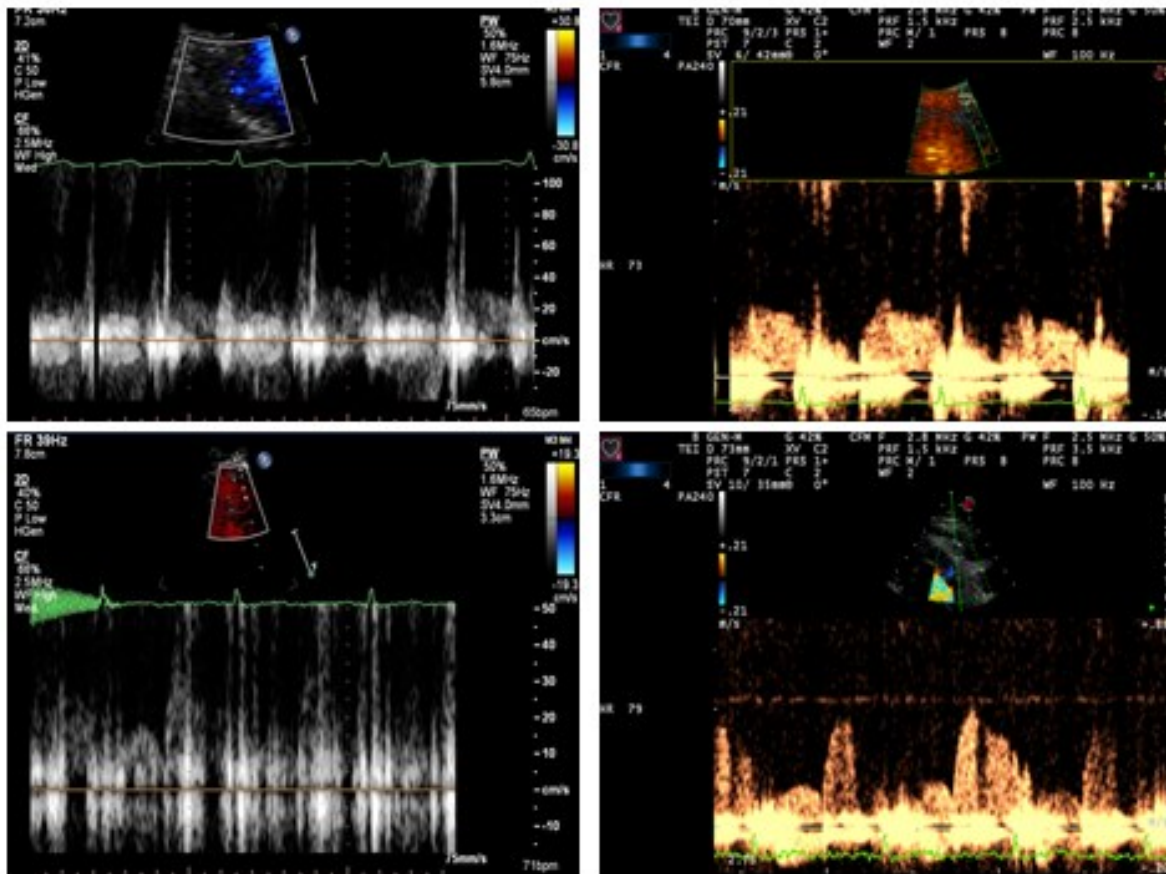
Pulse-wave Doppler of the left anterior descending artery in two patients using different machines.
